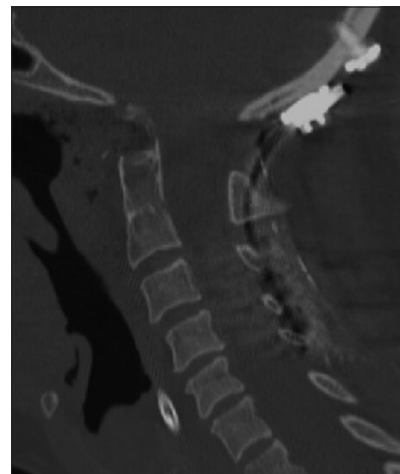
Postoperative lateral CT scan of the cervical spine demonstrating removal of the odontoid and reduction of compression on the cervical spinal cord.
